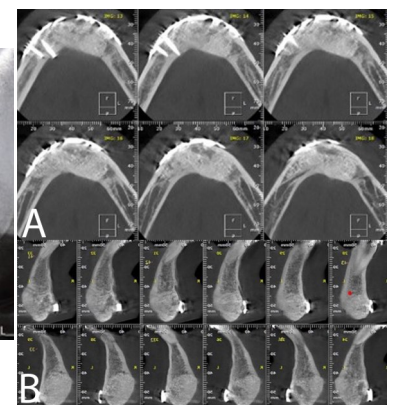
Computed tomography showed satisfactory bone density in the anterior region of the mandible.
